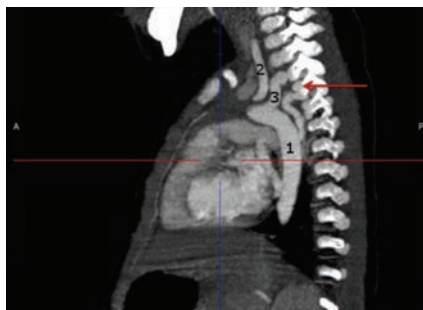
Angio-magnetic resonance imaging: abnormal dilated serpiginous vascular structure (red arrow) originating from the descending aorta with intraforaminal extension. 1: Descending aorta; 2: left vertebral artery; 3: subclavian artery.
